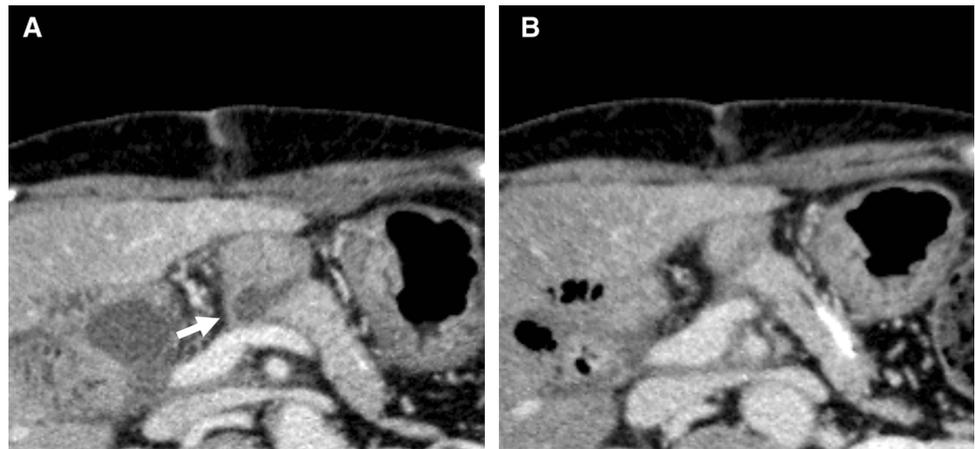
Computed tomography images. The fluid space between the elevated jejunum and remnant pancreas (A: arrow) disappears after the procedure (B)
